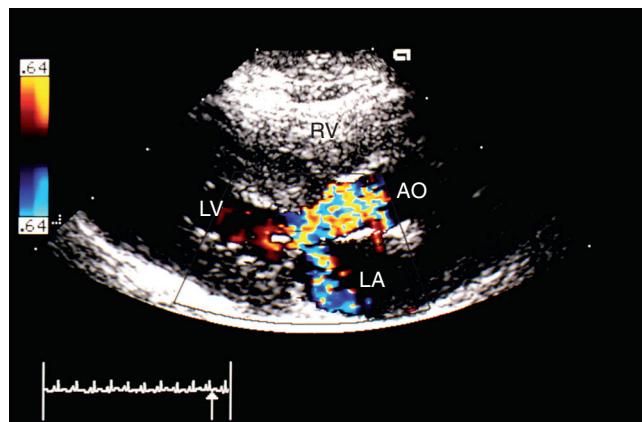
Right-parasternal long-axis color Doppler echocardiographic image demonstrating the divergent jets characteristic of systolic anterior motion of the mitral valve. Turbulence is seen extending into the aorta, and a second discrete jet is seen extending towards the posterior wall of the left atrium.
